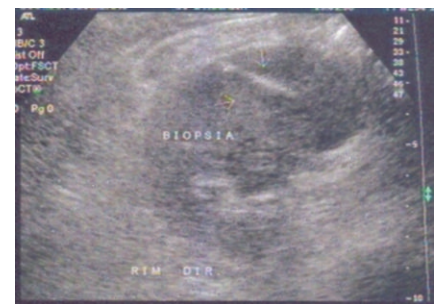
Tumor puncture guided by ultrasound.
